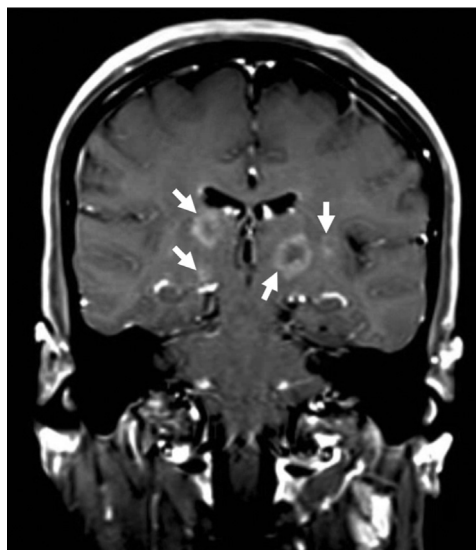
Magnetic resonance imaging of the brain, coronal T1-weighted post-contrast sequence. Ring-enhancing lesions (white arrows) are present within the bilateral thalami and right globus pallidus, consistent with cerebral toxoplasmosis.
